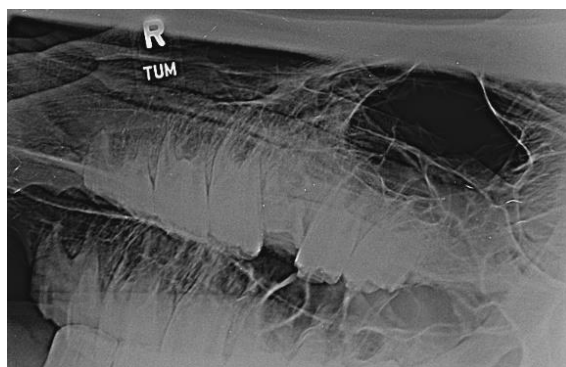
Radiographic image of upper right arcade
